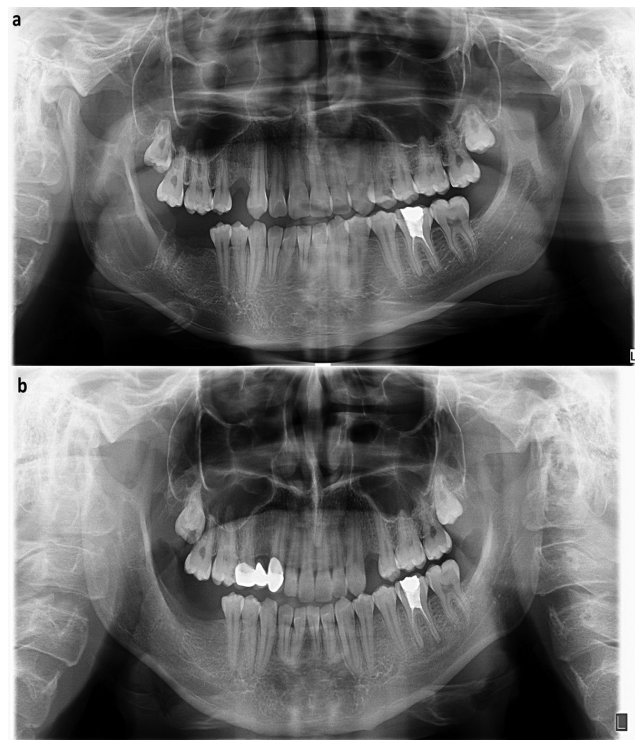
a) Preoperative radiographic view of the unilocular TBC in the right ramus region; b) Postoperative view at 18 month follow up with healing
